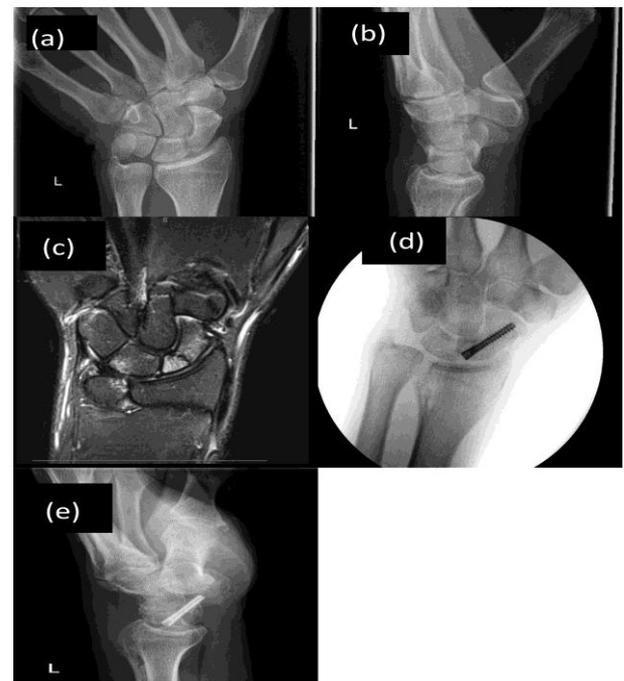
Missed scaphoid fracture from initial and repeat X-ray then diagnosed by MRI and treated operatively. (a) AP and (b) lateral view of the wrist two weeks after injury showed no scaphoid fracture. (c) MRI was done and showed a proximal scaphoid fracture which was treated operatively (d-e).
